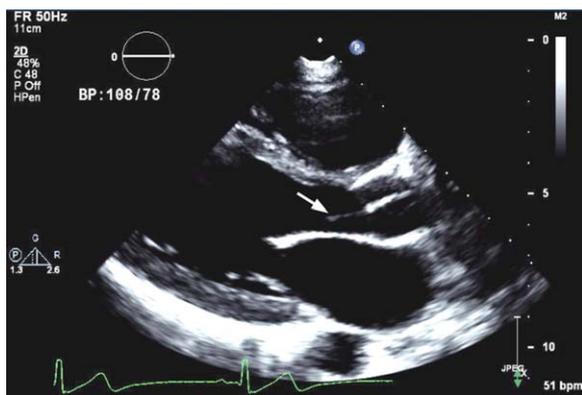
Parasternal long-axis echocardiograph demonstrating a long LE (arrow) from a 13-year-old male with an otherwise normal echocardiogram
